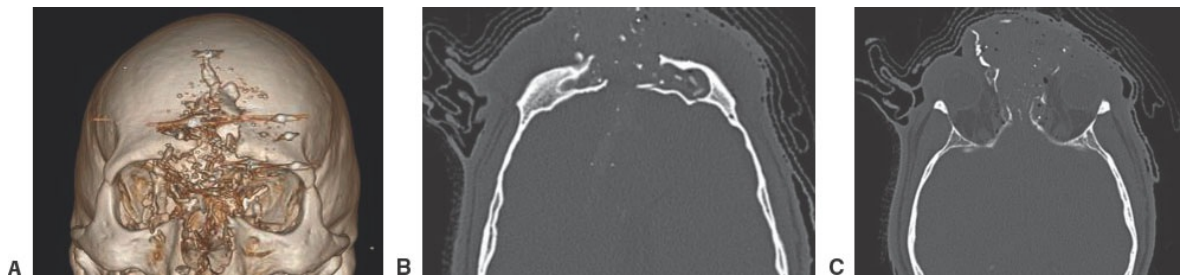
• A. 3D CT reconstruction demonstrating comminuted facial fractures with concomitant frontal sinus injury from the shotgun blast. B. Axial CT demonstrating massive injuries to the anterior and posterior tables of the frontal sinus with segmental bone loss. C. Axial CT image showing destruction of the frontonasal duct.
